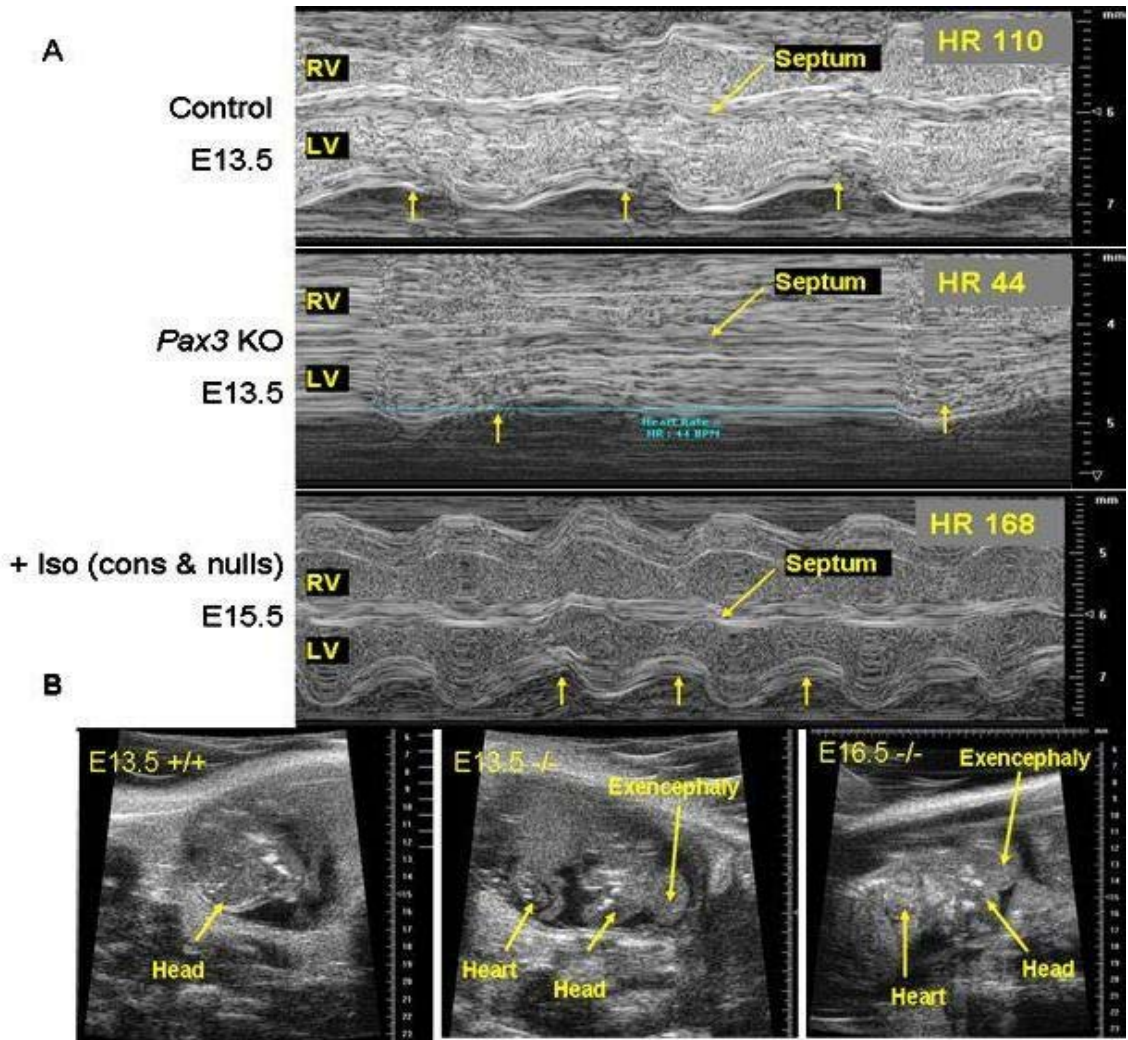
Echocardiography analyses show poor cardiac function in *Pax3*^{d5/d5} mutants are rescued by isoproterenol treatment
